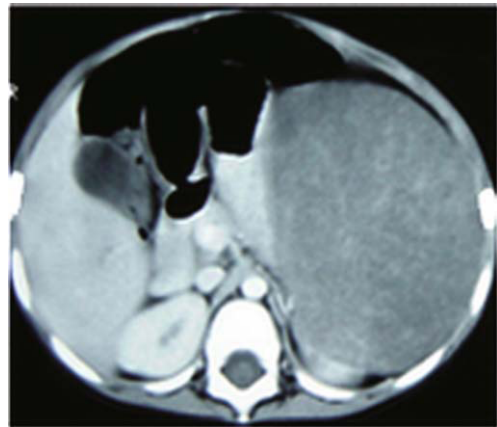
Enhanced CT showing late- or delayed-phase homogeneous contrast enhancement and no discrete mottled areas of heterogeneous attenuation.
